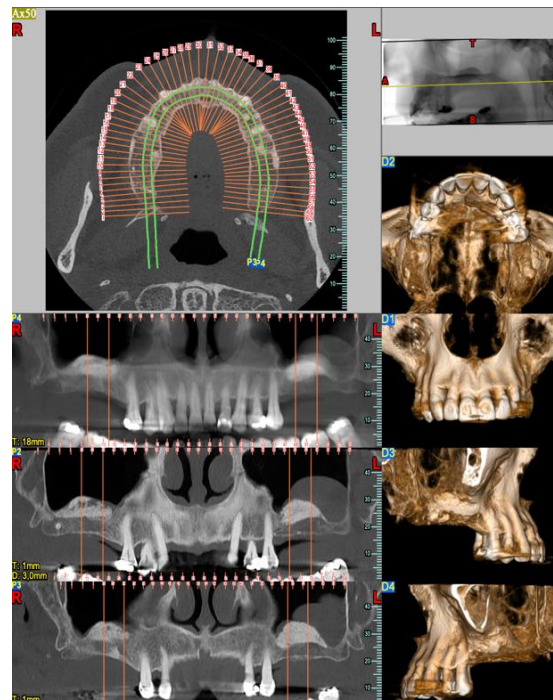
CBCT after sinus lift procedure on both maxillary sinuses.
